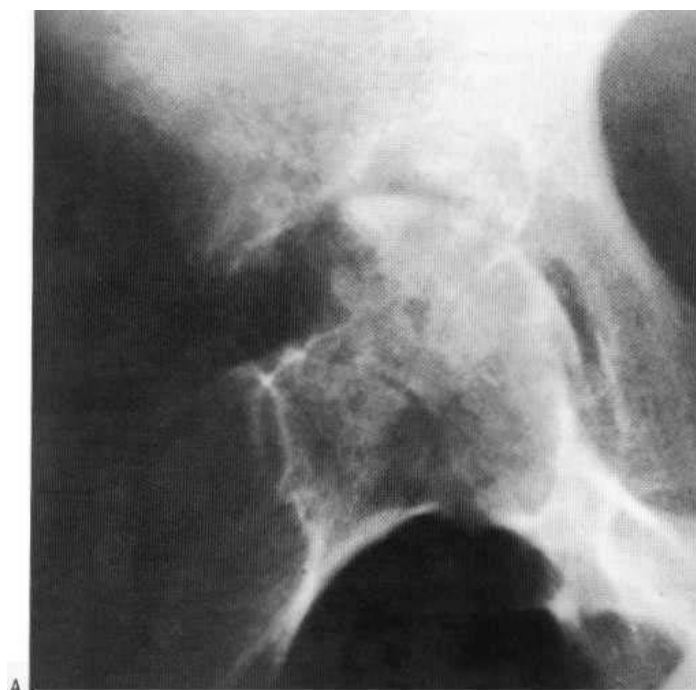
Synovial tuberculosis. (A) The plain film shows bone and cartilage destruction on both sides of the joint. (B) The arthrogram shows gross irregular synovial hypertrophy. The geode does not fill.
